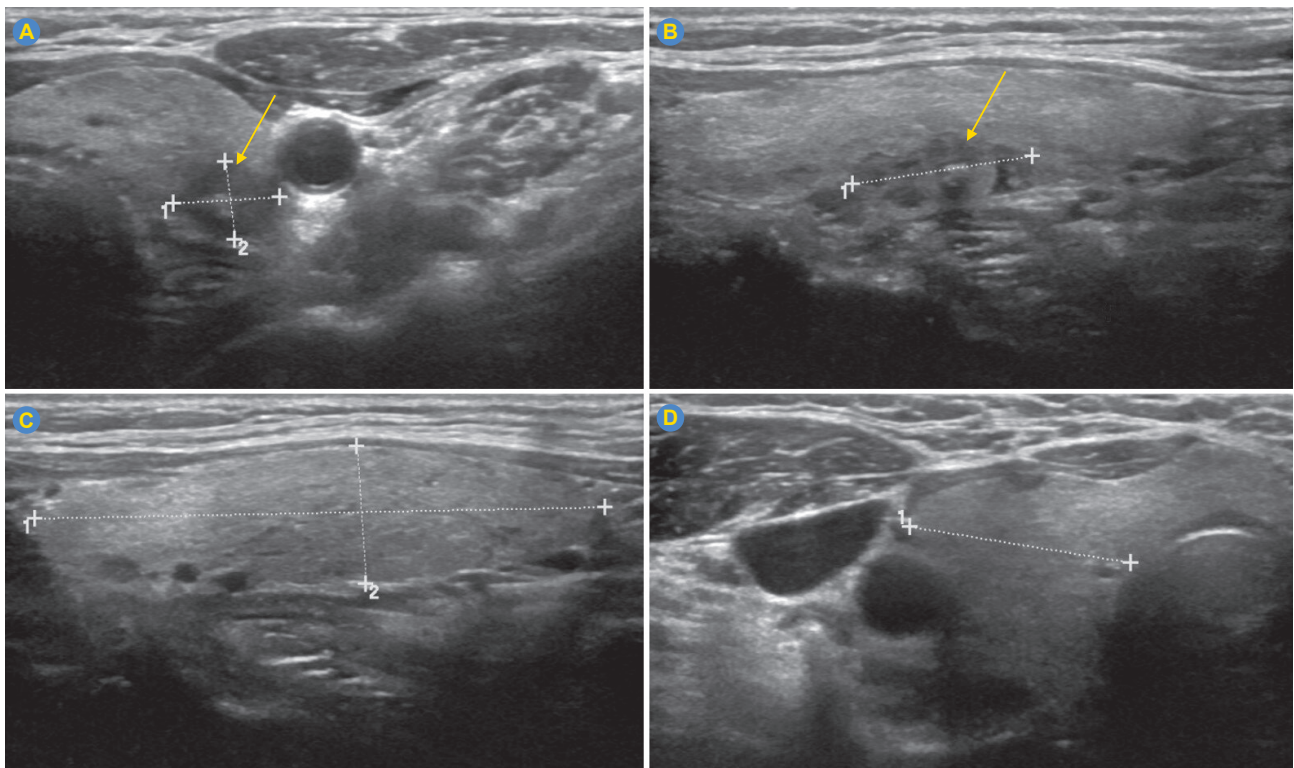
B-mode ultrasound of the thyroid shows a hypoechoic well-defined solid nodule in the posterior margin of the left thyroid lobe (arrow), with a fine-needle aspiration result of follicular lesion of undetermined significance (A, B). The location of the nodule in the posterior portion of the lobe makes the case unfavorable for the TOEVTA approach. The remaining characteristics of the nodule and the gland (C, D) are not impeditive.
